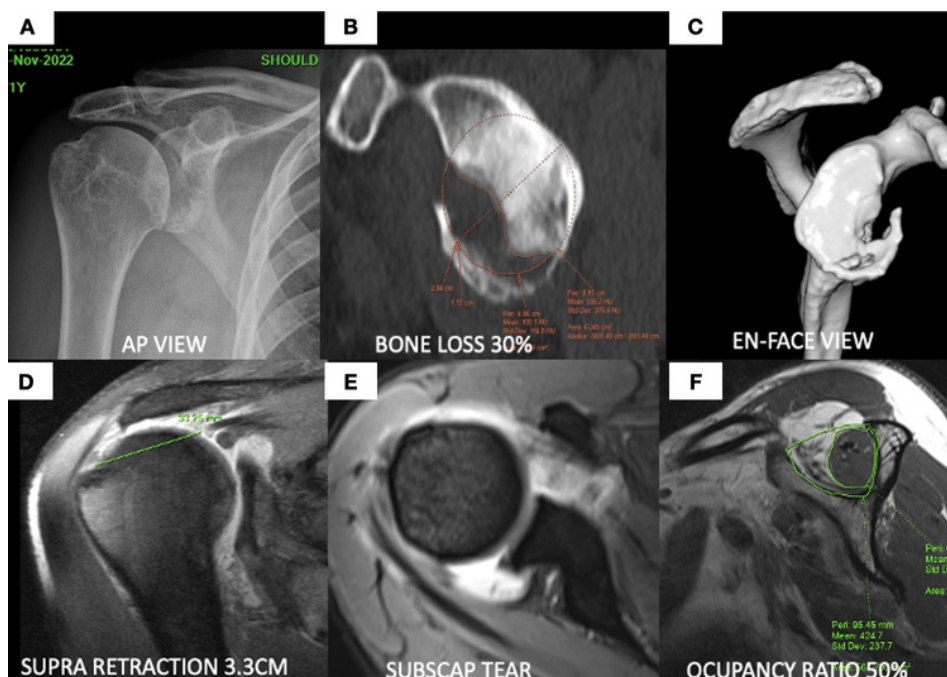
Pre-operative imaging . A: Plain radiograph, B&C: CT images, D, E, F: Coronal, axial and sagittal MRI cuts.
